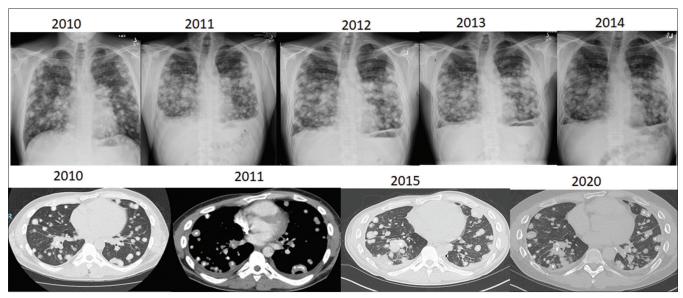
Upper row chest X-ray images (2010–2014) and lower row computed Tomography-chest (2010, 2011) images showed multiple slowly progressive pulmonary nodules
